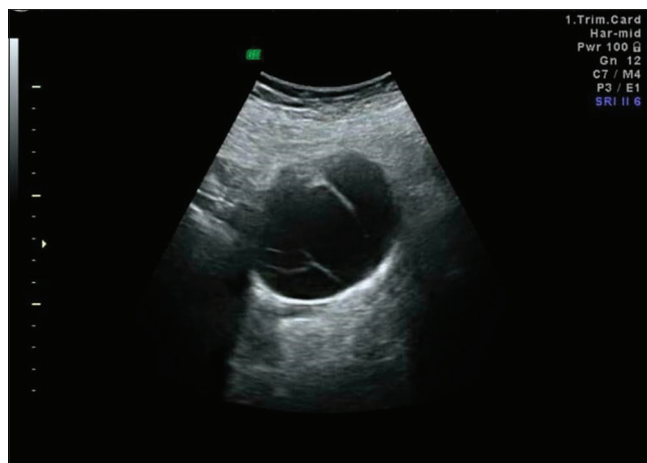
Gynecologic Imaging Reporting and Data System III. A cyst with some thin septa, without any nodule or vascularity. No vascularity was detected in Doppler study
